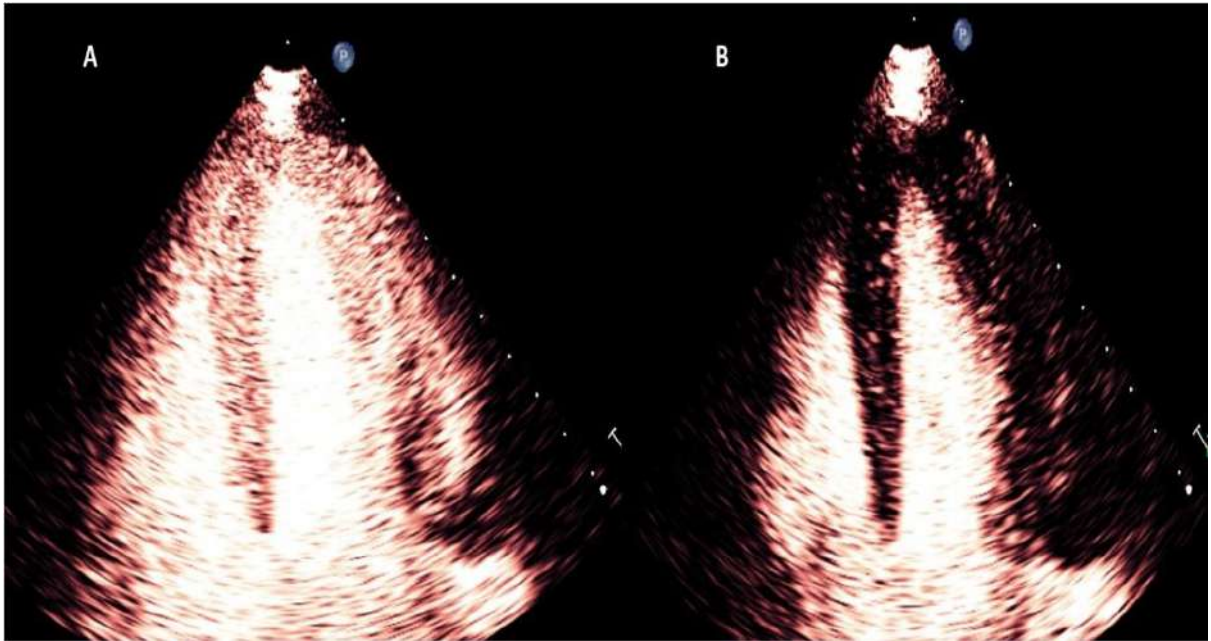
Myocardial contrast echocardiography images of left ventricle in the apical 4-chamber view. A – showing myocardial contrast opacification. B – showing microbubble destruction in the myocardium after flash echocardiography.
